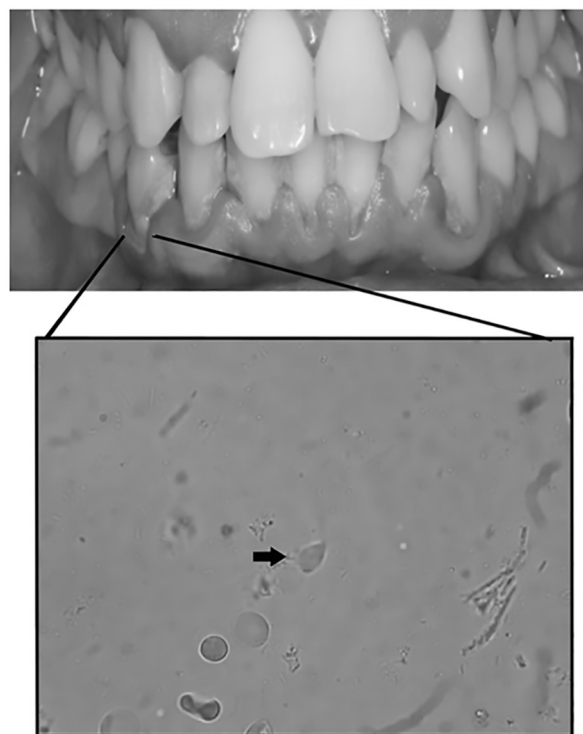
Panoramic oral radiograph of a patient with periodontitis (top) and *Trichomonas tenax* isolated from dental plaque (bottom). 400x magnification (C. Brecamonte-Wolf et al., 2019).
